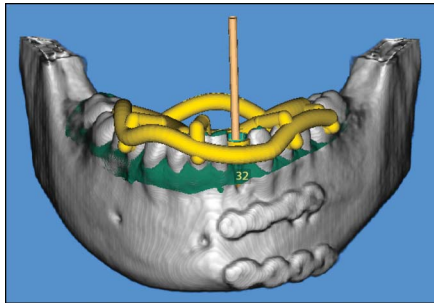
Screenshot from the virtual implant planning and template design in SMOP. The preoperative CBCT scan (gray) from the lower jaw is superimposed with the intraoral scan (green) of the mandibular teeth. On these scans, the implant position for the missing lower lateral incisor and the drill template design is planned digitally (yellow).
